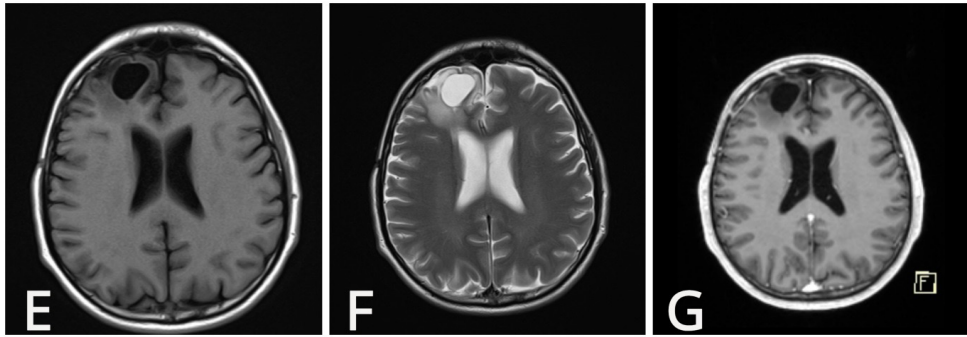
Postoperative brain MRI images on the first check-up, Axial view T1-weighted image (T1WI). (E) Axial view, T2WI. (F) Axial view, contrast-enhanced T1WI (G). A cystic formation in the operative region, without any signs of tumor residue
